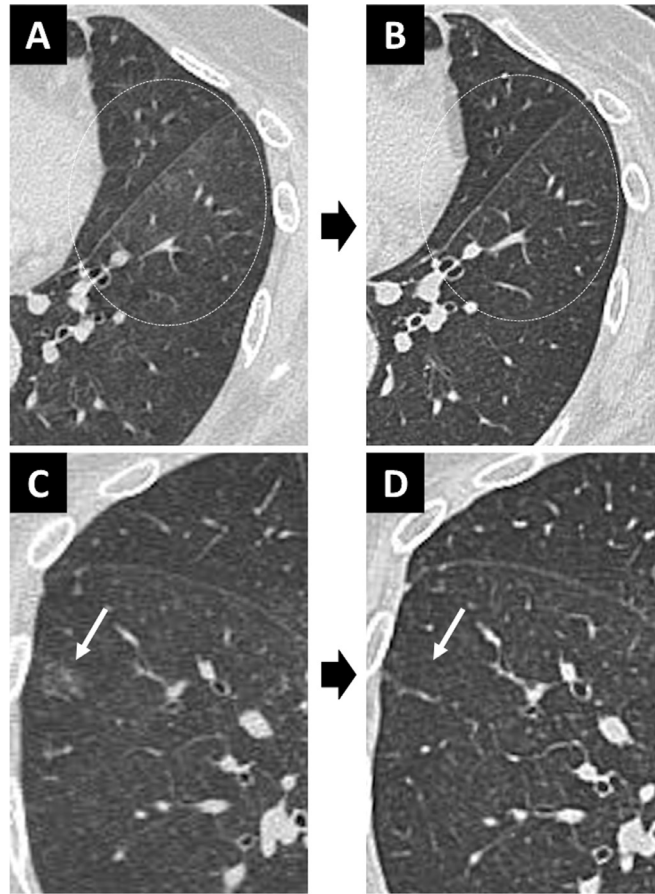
(A, B) Chest computed tomography at the emergency department visit. Diffuse faint ground-glass opacities are seen in bilateral lung fields. Ground-glass opacities are defined as a hazy increased attenuation in the lung that does not obscure the pulmonary vascular markings.
